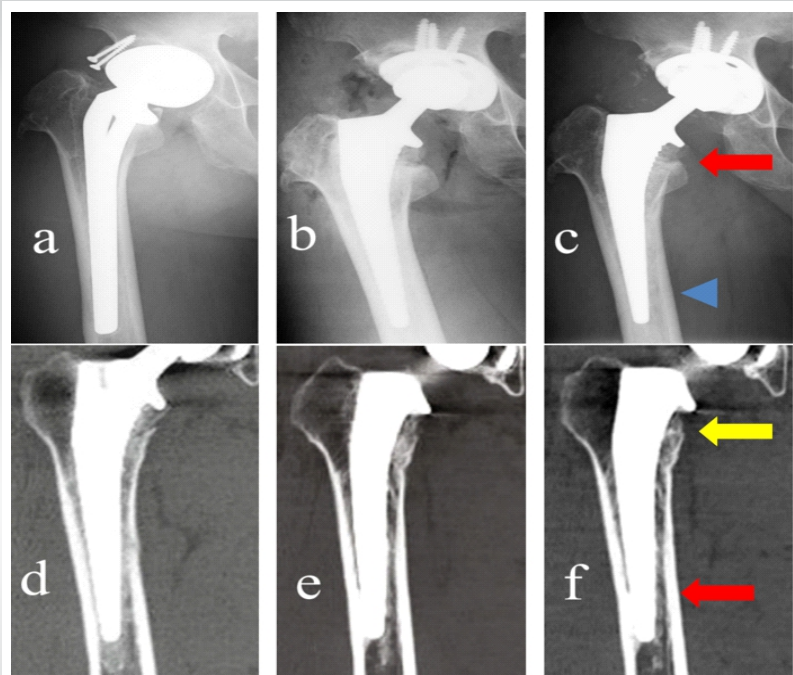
X-ray and computed tomography (CT) images in Case 1. (a) 10 years post-operative X-ray. (b) X-ray after revision surgery. (c) X-ray eight and a half years postoperatively. The allograft bone at the greater trochanter had integrated, making the boundary with the host bone indistinct (red arrow). Cortical hypertrophy at the distal stem had not progressed (blue arrowhead). (d) CT images taken 3 months post-surgery. (e) CT images taken 2 years post-surgery. (f) CT images taken 5 years post-surgery revealed remodeling of the bony mass in the calcar region (yellow arrow) and remodeling and bone growth in the allograft cancellous bone layer around the stem (red arrow).
